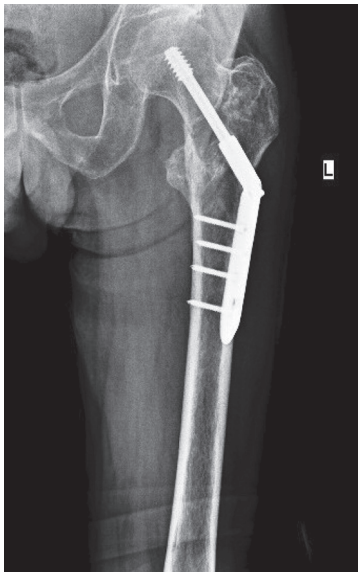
Anteroposterior radiograph of the left thigh shows an appearance one year after surgery of the femur treated with a Dynamic Hip Screw (DHS) plate
